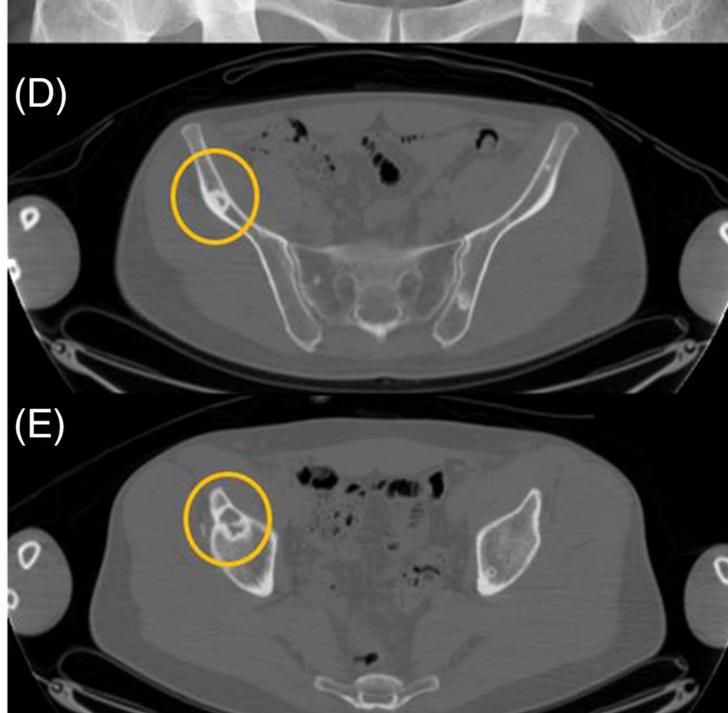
Manifestations of POEMS syndrome. (A) Optic disc edema. (B) Skin changes including white nails and cyanosis. (C-E) Mixed lytic osteosclerotic bone lesions on plain radiograph (C) and CT scan (D and E).³
